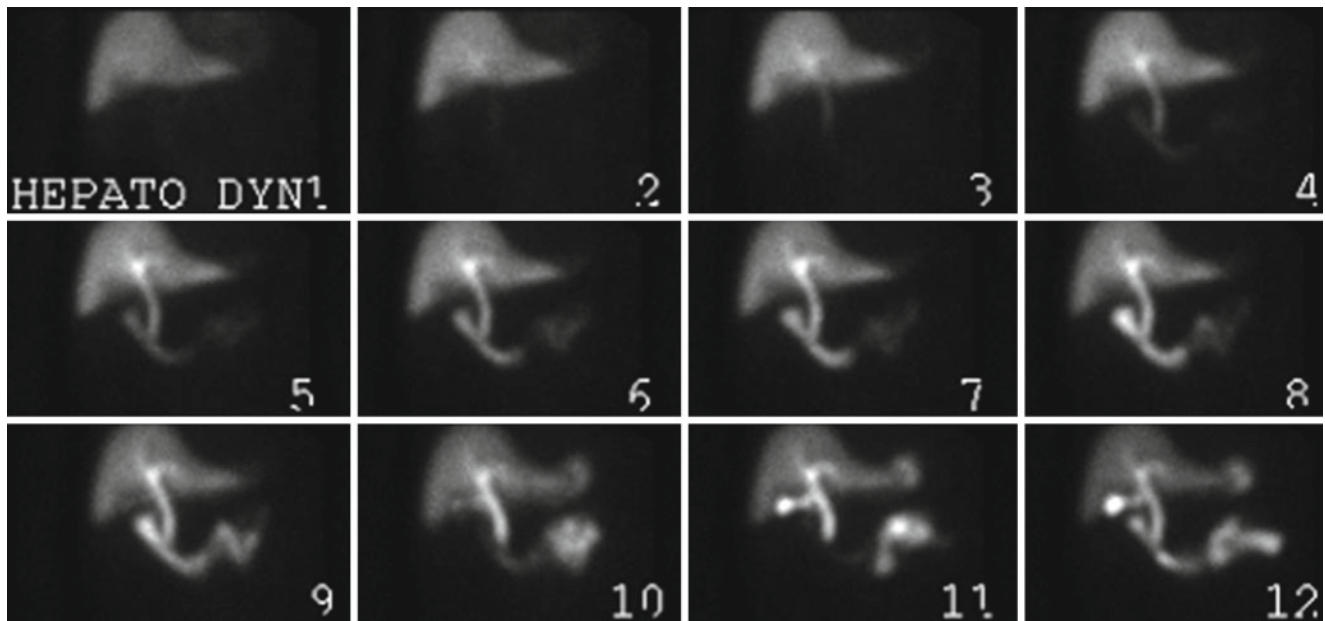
Normal hepatobiliary scintigraphy showing prompt filling of the CBD, gallbladder, and small bowel
